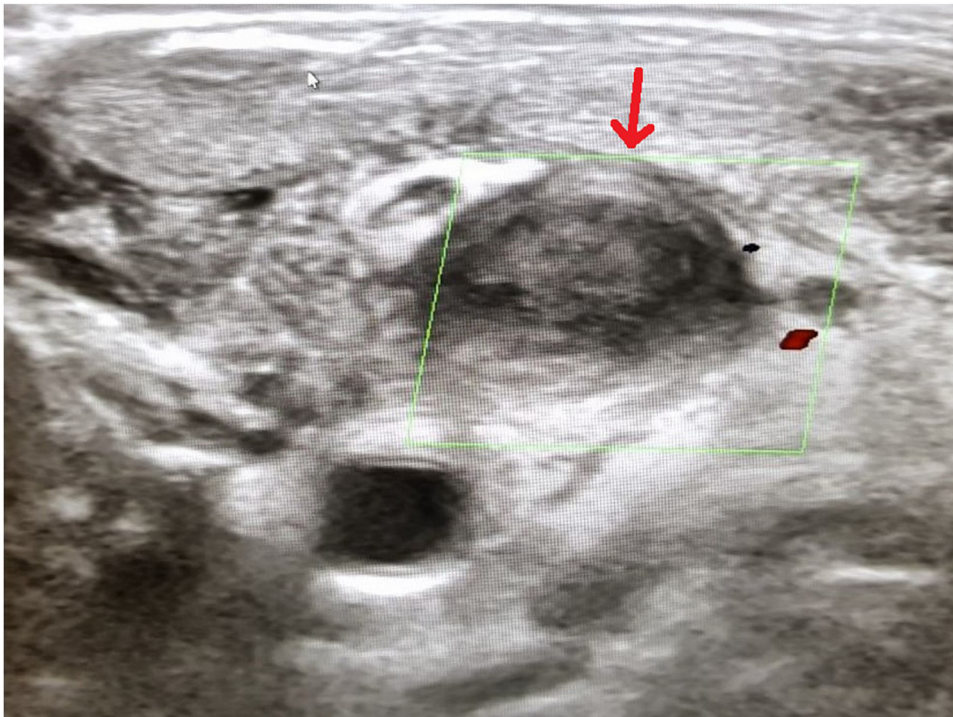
Colour flow Doppler ultrasound of the neck showing a large echogenic thrombus in the left internal jugular vein (red arrow).
